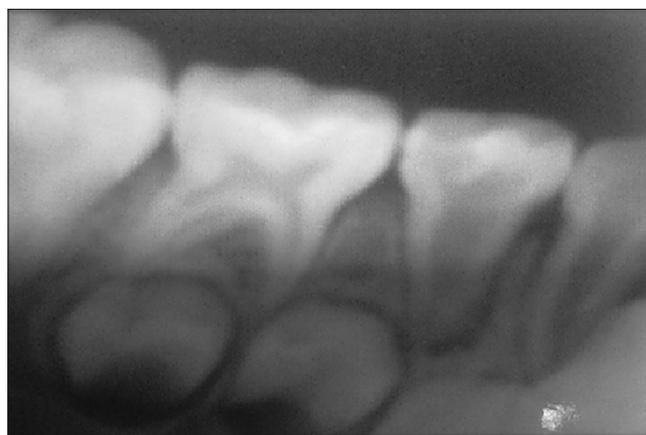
Intra oral periapical radiograph of 84.
